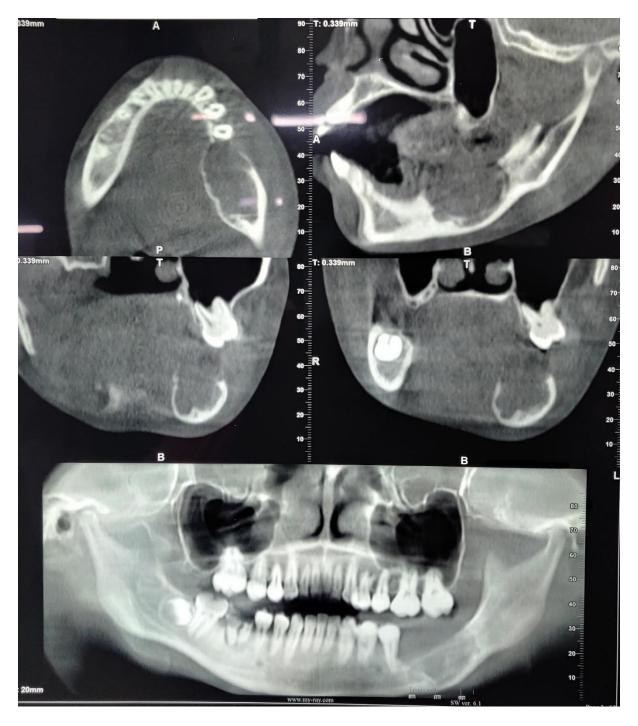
CBCT showing a radiolucent lesion involving the left body of the mandible with expansion of both buccal and lingual cortices seen on axial and coronal sections
